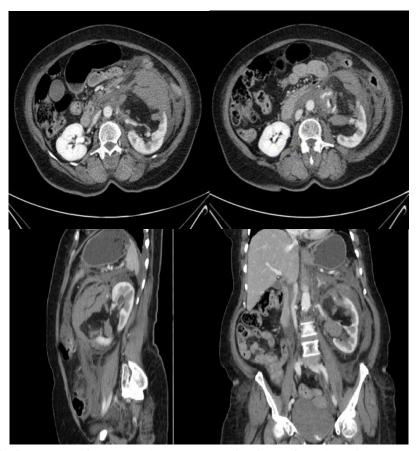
Abdominal and pelvic CT scan with IV contrast (transverse, sagittal, and coronal views). A soft tissue mass consists of fat tissue and blood vessels in the left kidney, mild right perinephric fluid, and adipose tissue inflammation in the left perineal space. Free fluid around the retroperitoneal vessels and the left colon down to the pelvic cavity were reported.
